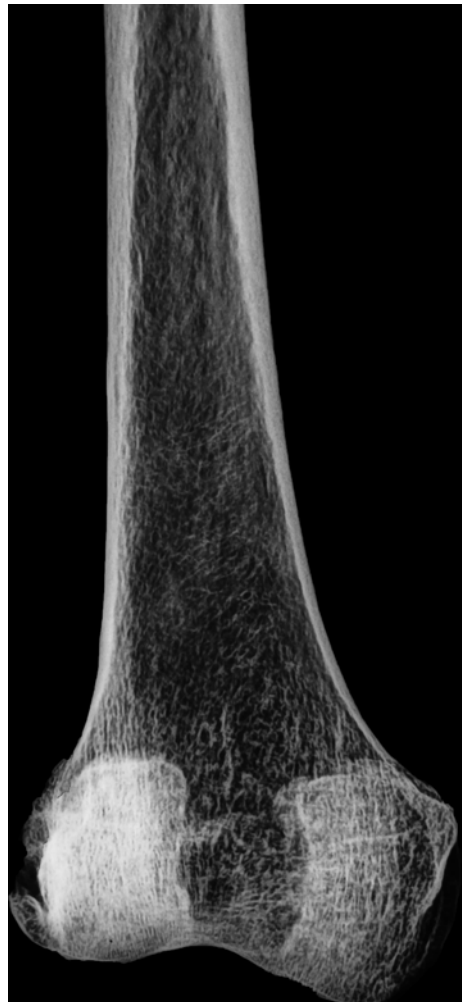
X-rays antero posterior view of the distal femur shows an area of hyper-opacity at the lateral condyle, due to subchondral sclerosis, a sign of arthritis of the knee joint
